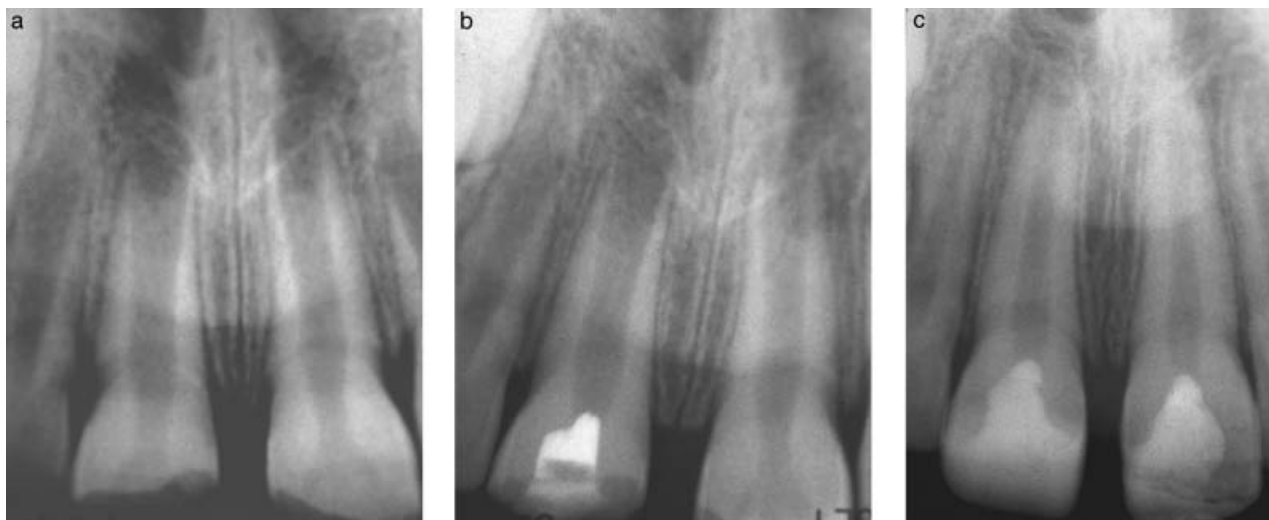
The use of mineral trioxide aggregate (MTA) for vital pulp therapy. (a) Two fractured central incisors in an 8-year-old boy who suffered a traumatic accident. The pulps in both teeth were exposed. (b) Radiograph shows initial treatment with MTA in the right incisor; the same procedure was performed on the left incisor. (c) Radiograph of the two incisors 3 years post-treatment. Note the continued root development indicating normal pulpal function in both teeth.
